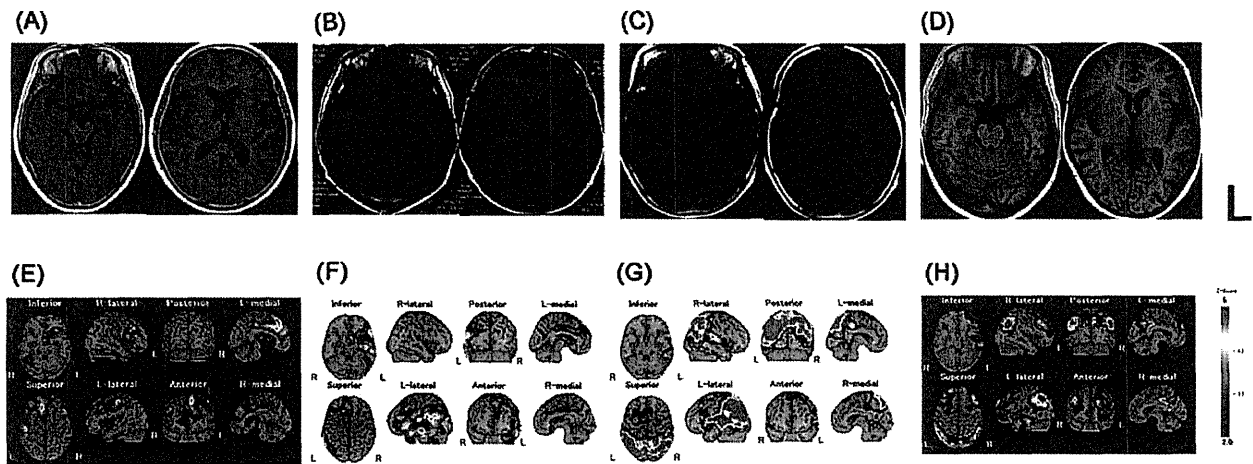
MRI and ^{99m}Tc ECD-SPECT. Brain MRI of PPA patients for naPPA (A), lvPPA (B), svPPA (C) and early-onset AD (D). ^{99m}Tc ECD-SPECT of patients for naPPA (E), lvPPA (F), svPPA (G) and AD (H). naPPA is characterized by predominant atrophy (A) and hypoperfusion (E) in the left posterior fronto-insular region, svPPA by predominant atrophy (B) and hypoperfusion in the left anterior temporal lobe (F), and lvPPA by predominant atrophy (C) and hypoperfusion in the left posterior perisylvian or parietal region (G). An early-onset AD patient showed frontal and temporal lobes atrophy (D), and hypoperfusion in the frontal lobes and parietal lobes cortices and the posterior cingulate (H).
